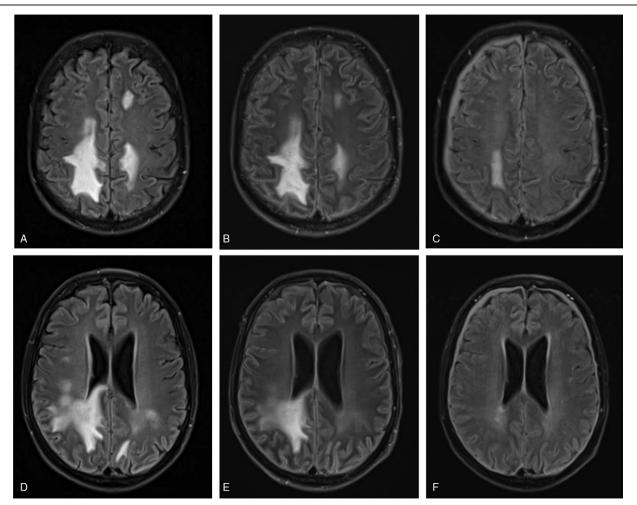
HLH-associated T2-/FLAIR-weighted white matter hyperintensities parietal (A–C) and around periventricular regions (D–F) in axial plane. (A+D) ICU admission (day 5 after admission), (B+E) after 4 plasma exchange procedures (day 13 after admission), (C+F) under maintenance therapy (day 68 after admission). FLAIR=fluid-attenuated inversion recovery, HLH = hemophagocytic lymphohisticytosis
